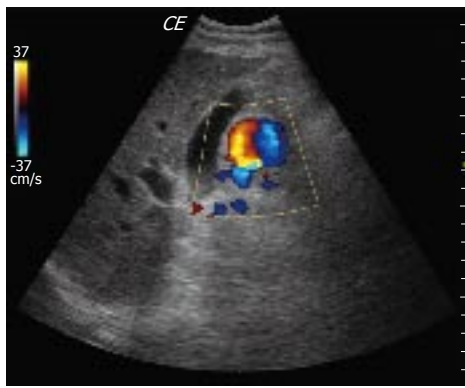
Color-Doppler US showed an anechoic mass, 2.5 cm in diameter, next to the head of the pancreas with turbulent flow inside.
